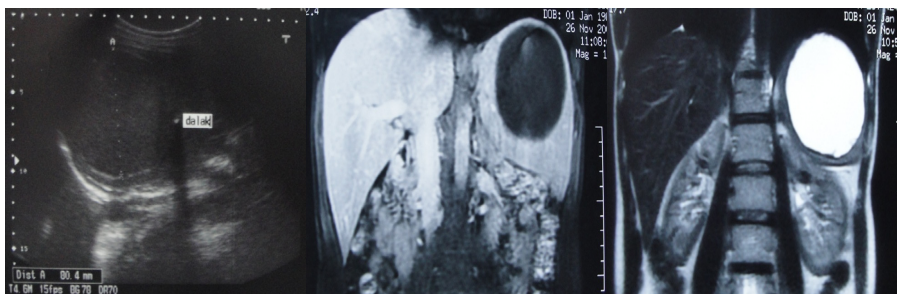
Ultrasonographic findings (a), cystic mass in spleen with 8 cm diameter, homogeneous internal structure and peripheral brightly echogenic foci with distal shadowing due to calcifications within the wall. MRI image in coronal section: (b) a cystic mass covering the splenic center, well defined border, homogeneous inside and obvious hypointense signaling with T1-weighted images, (c) obvious hyperintense signaling and homogenous inside with fat suppressed T2 analysis
